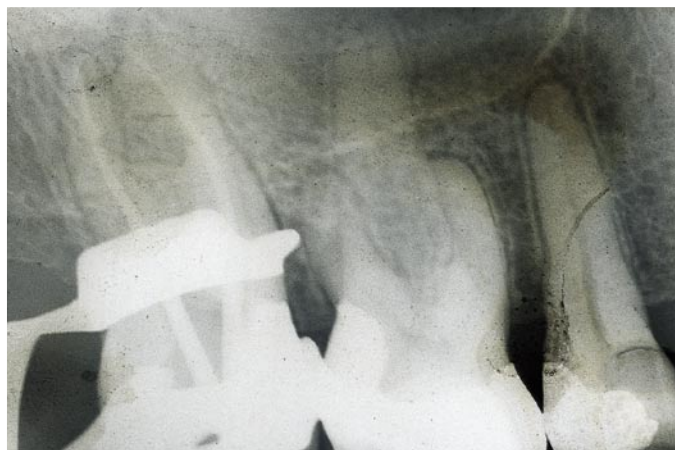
The radiograph was not rinsed properly. At the level of the clip, there are large streaks of the fixer solution, evidently still present in the rinsing water.
